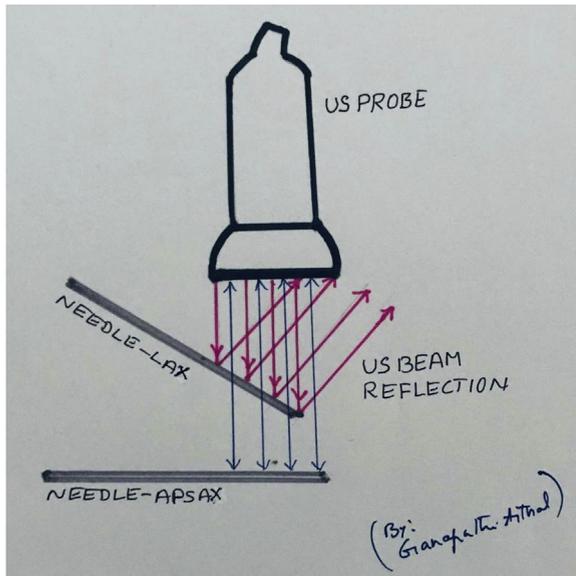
Ultrasound (US) beam reflection and needle orientation in the long axis (LAX) and anteroposterior short axis (APSAX) views.
